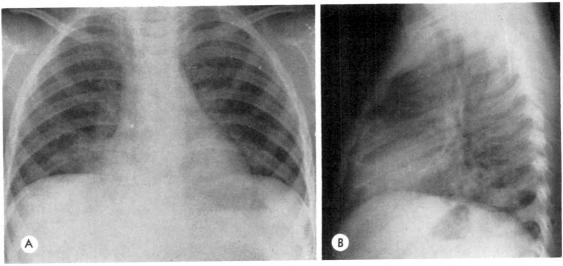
Case 1. Chest roentgenograms taken 7 hours after ingestion of furniture polish. (A) Frontal roentgenogram shows mild mottled densities adjacent to both lower heart borders. (B) Lateral roentgenogram shows the densities in the lower lobe and perihilar areas.
